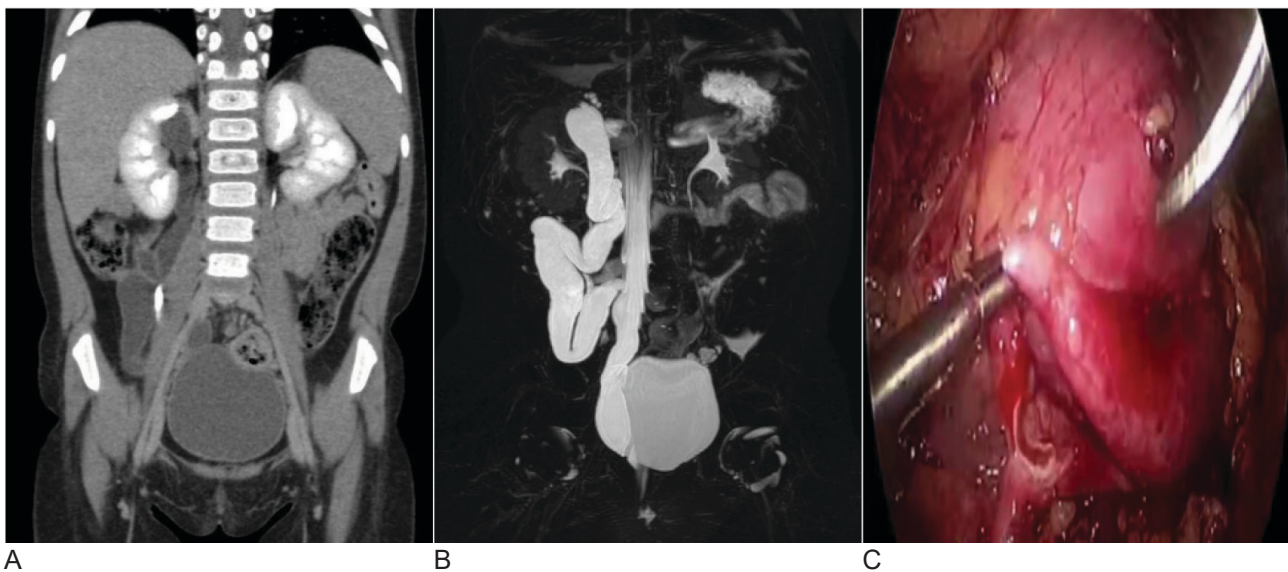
Images of MRI and CT in Diagnosing Duplication of Kidney in Children
